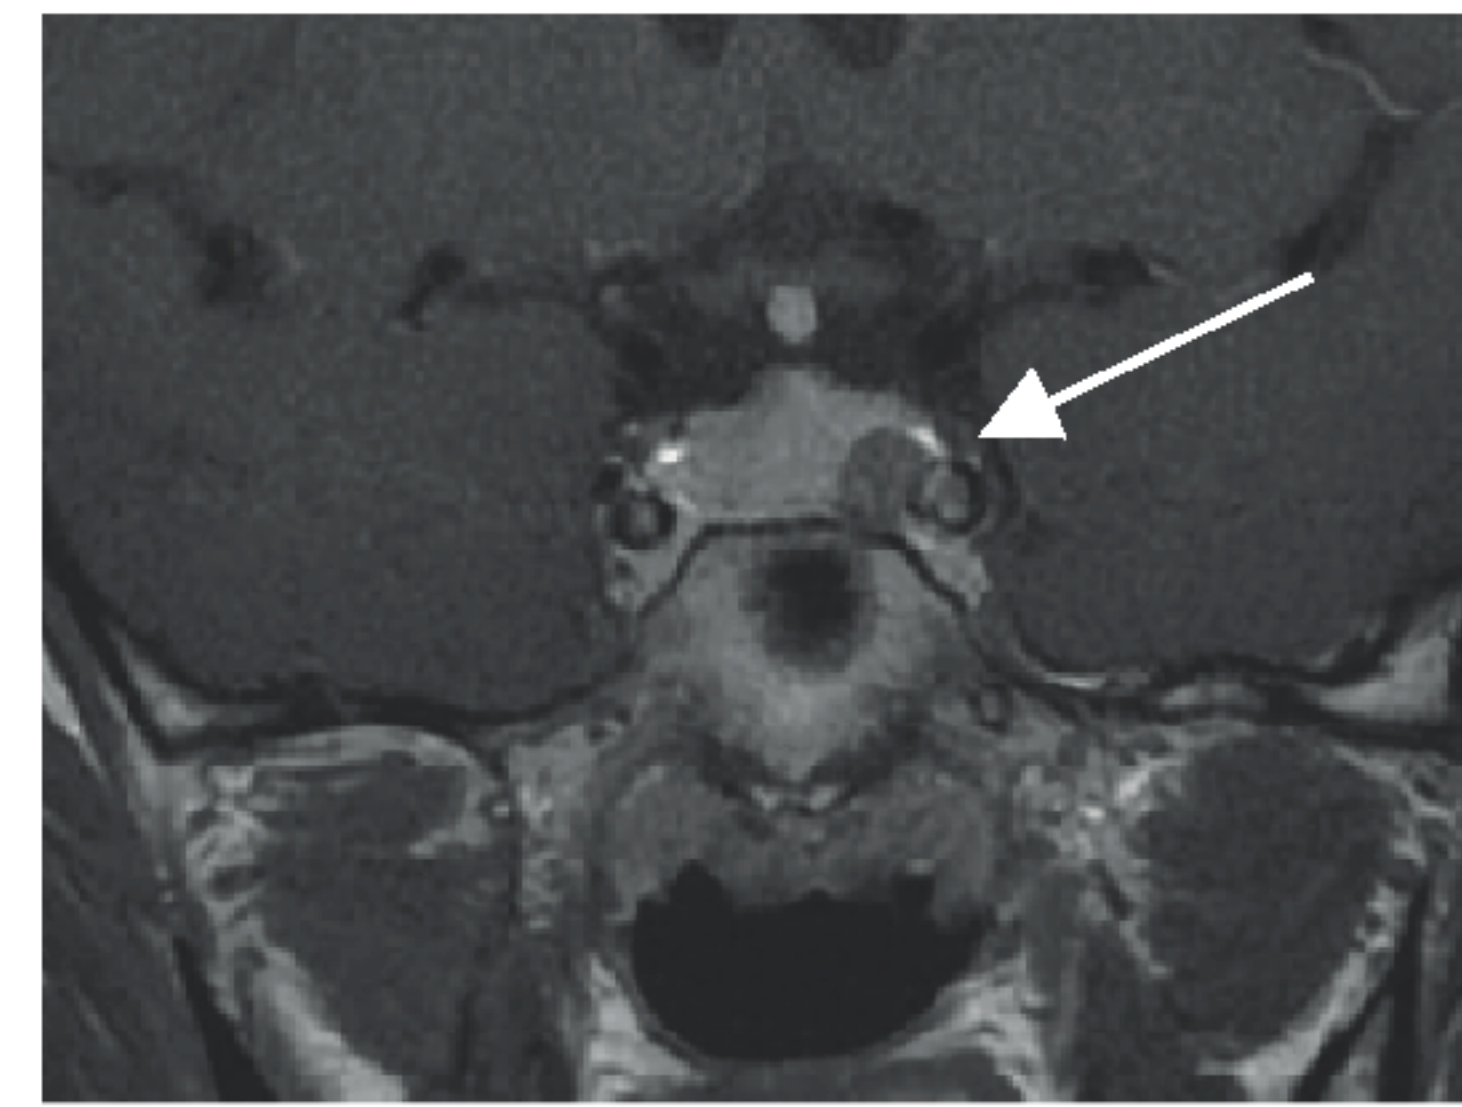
MRI of the patient before surgery showing the left pituitary microadenoma.
